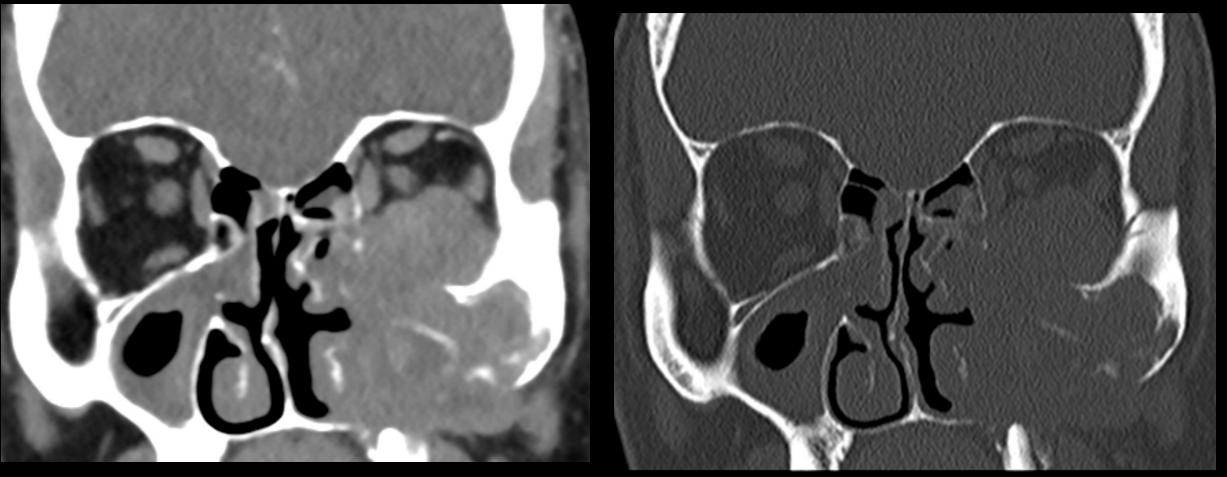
Coronal CT post-contrast soft tissue and bone window demonstrating left maxillary sinus soft tissue mass with destruction of adjacent bony structures and orbital extension.
